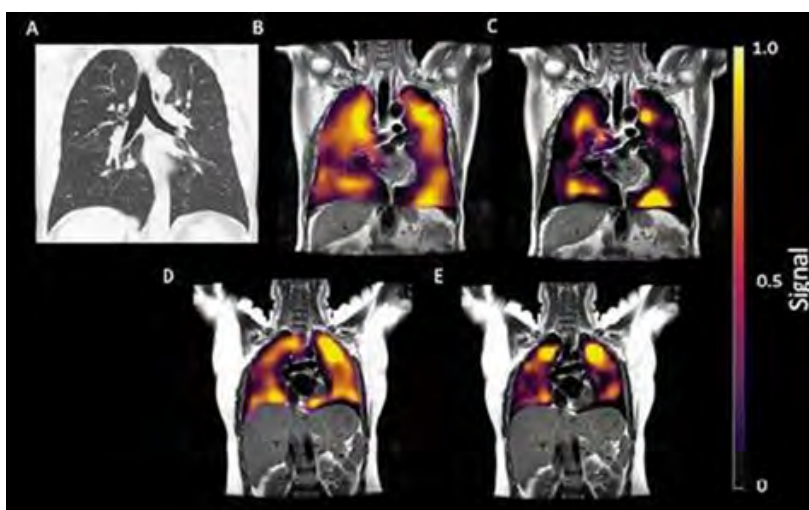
Images taken 172 days after discharge in a 60-year-old patient with a history of dyspnea following COVID-19 [top row]. CT, breathing, and red blood cell [RBC] phases of hyperpolarized xenon 129 MRI [A–C] [XeMRI]. Images of a healthy control volunteer [bottom row] during the gas and RBC stages. Both individuals' XeMRI images are displayed in coronal view, with damaged RBC in the patient.
